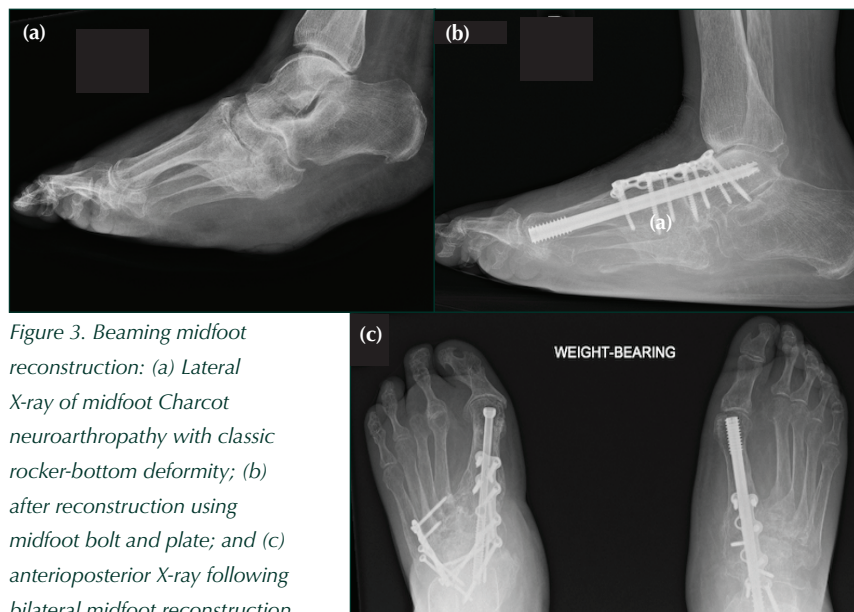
Beaming midfoot reconstruction: (a) Lateral X-ray of midfoot Charcot neuroarthropathy with classic rocker-bottom deformity; (b) after reconstruction using midfoot bolt and plate; and (c) anteroposterior X-ray following bilateral midfoot reconstruction.
